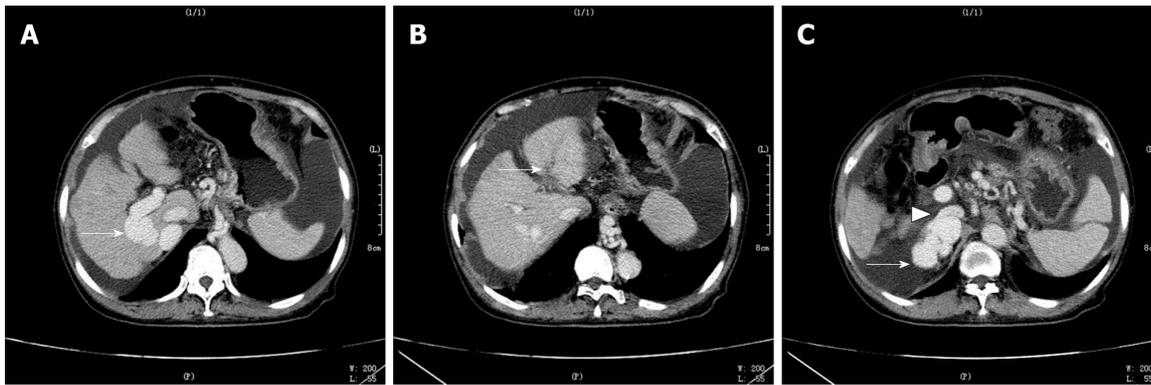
Abdomen enhanced computed tomography revealed a spontaneous intrahepatic portosystemic shunt. A: The right branch of portal vein (PV) was thick and showed vermicular dilatation vein cluster (arrow); B: The left branch of PV was thin and occluded (arrow); C: The right branch of PV connected with inferior vena cava (arrowhead), extrahepatic dilatation and distortion of blood vessels (arrow).
